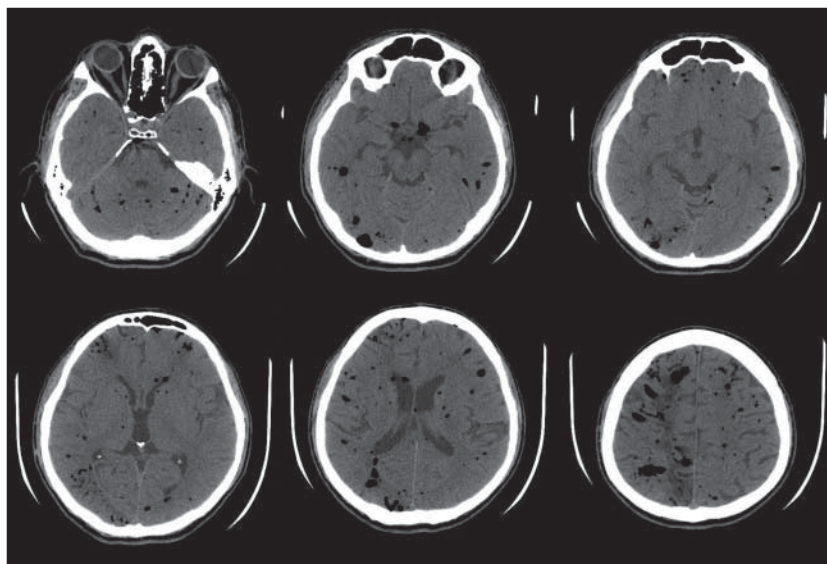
Axial brain computed tomographic scans. Multiple and bilateral areas of decreased attenuation identified intraparenchymal air pockets.
